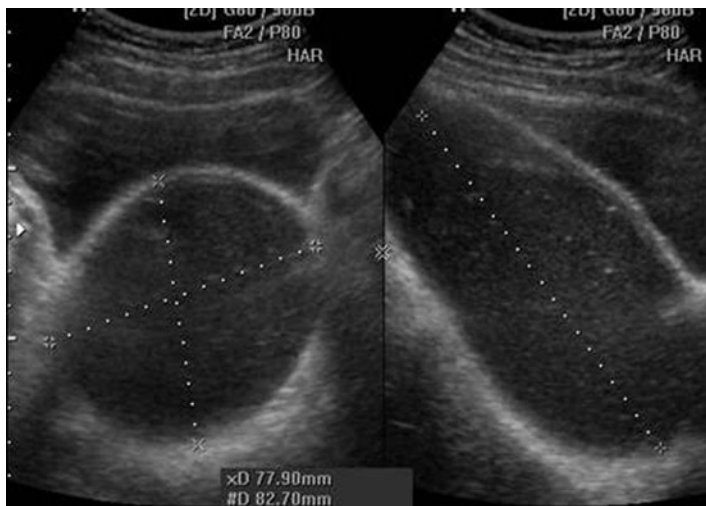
Ultrasound: Hypoechoic fluid content distending the uterus and vagina.
